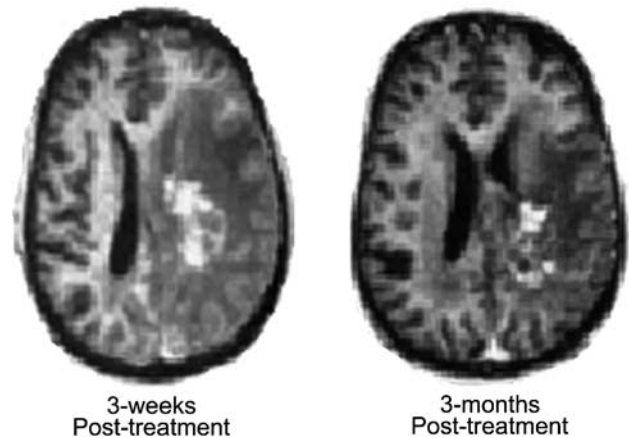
Post-treatment MRI scans of patient 3 following vaccination with TGF- β 2 antisense-modified autologous tumor cells. MRI scans obtained 3 weeks following treatment showed increased contrast enhancement at the tumor site (left panel). The patient declined further therapy and received only decadron to control inflammation. At 3 months following treatment, the increased contrast enhancement had resolved (right panel), suggesting either a delayed response to therapy or the resolution of inflammation following therapy.
